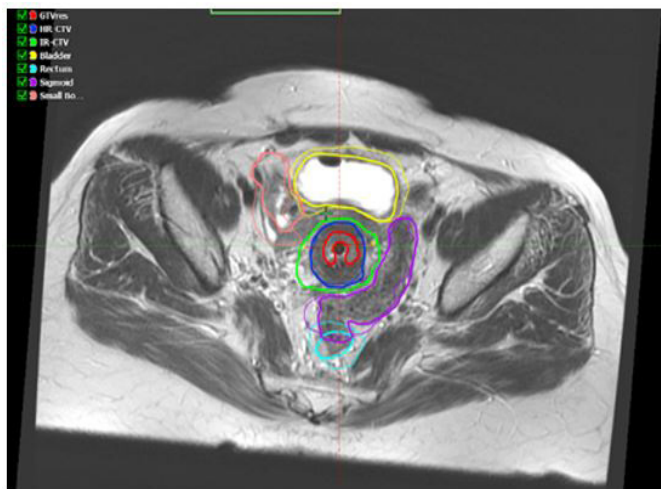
Superposition of OARs (bladder (yellow), rectum (cyan), sigmoid (purple), small bowel (pink)) and CTV (HR-CTV (blue), IR-CTV (green)) contours from MRI₁ to MRI₂ after rigid registration. Thick lines represent OARs delineated on MRI₂ geometry whereas normal lines represent OARs delineated on MRI₁ geometry and transferred to
